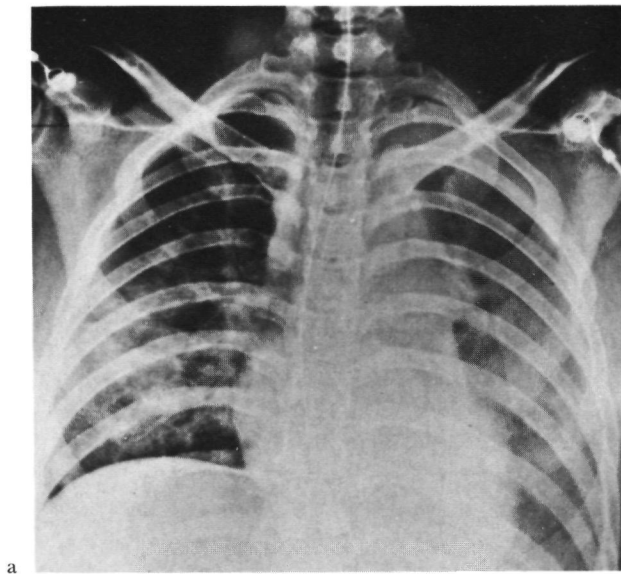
5 Male, 18 years, motorbike-driver, patient 8 with CTAR. a. Chest X-ray on admission 19.07.1971: unsharp aortic outline; multiple rib fractures; apical cap. Contusion of left lower lung. (Underpenetrated low KV chest X-ray, evaluation of tracheal position not possible). Diagnosis of TAR missed. b. and c. Chest X-rays at the time of detection of CTAR (1981): tracheal displacement to the right; abnormal configuration below the aortic knob (arrows); calcified mass lesion on the lateral chest X-ray (arrows). d. Angiography: false aneurysm at the level of the aortic isthmus.
